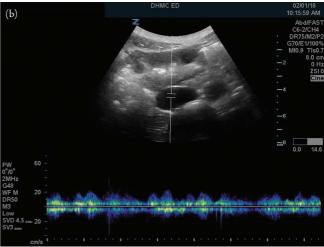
(a) Pulsed-wave Doppler triphasic arterial waveform. (b) Monophasic venous waveform.
